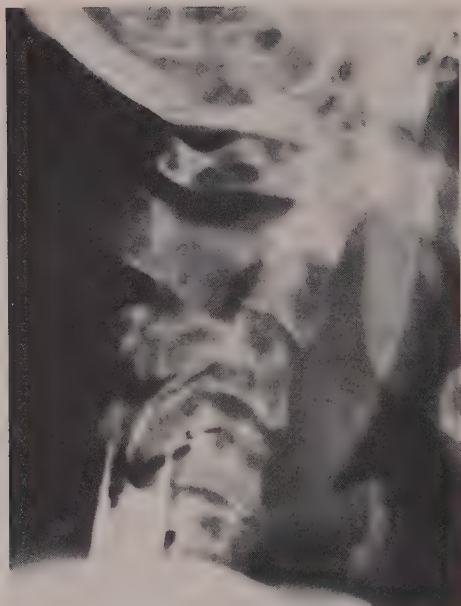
Epidural spinal cord compression from malignant lymphoma. In this patient, there was a complete block to the passage of myelographic contrast material at C4. There were no lesions on plain x-ray films or on bone scan. The tumor had grown from a paravertebral neck mass through the intervertebral foramen.
